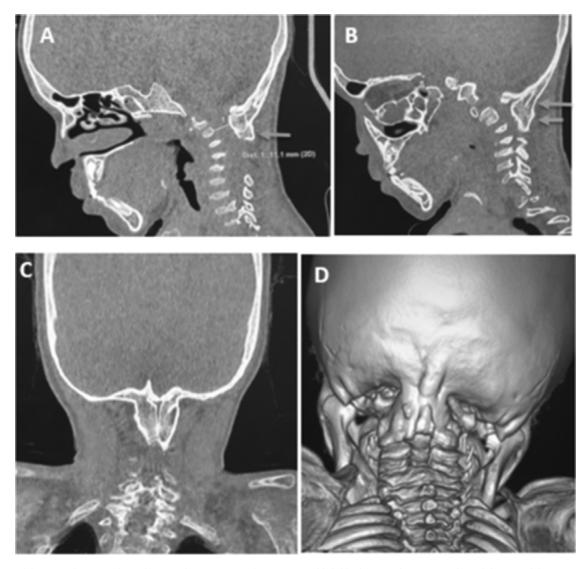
CT scan of the cervical spine performed 12 months postoperatively in a 4-year-old child. The sagittal section (A) showed the normal dimension of the foramen magnum and the cervical canal. The orange arrows showed the aspect of the occipito-C2 arthrodesis in sagittal (A and B), coronal (C) sections and in posterior view in 3D (D).
